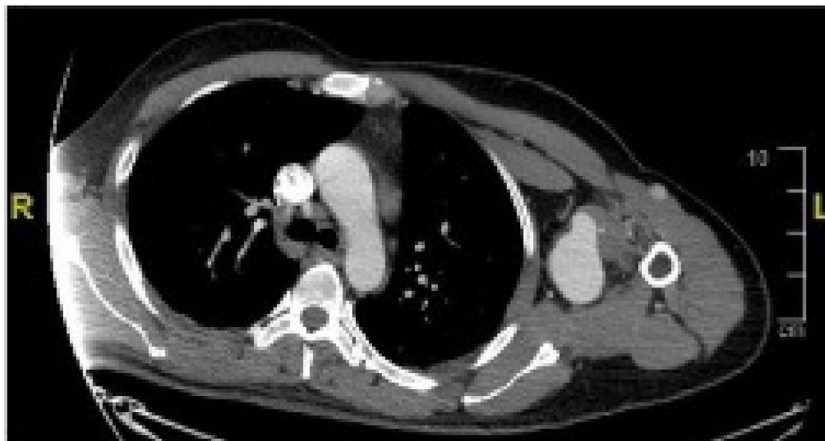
Computed tomography angiogram showing the axillary artery aneurysm with a maximum diameter of 5.1 cm.
